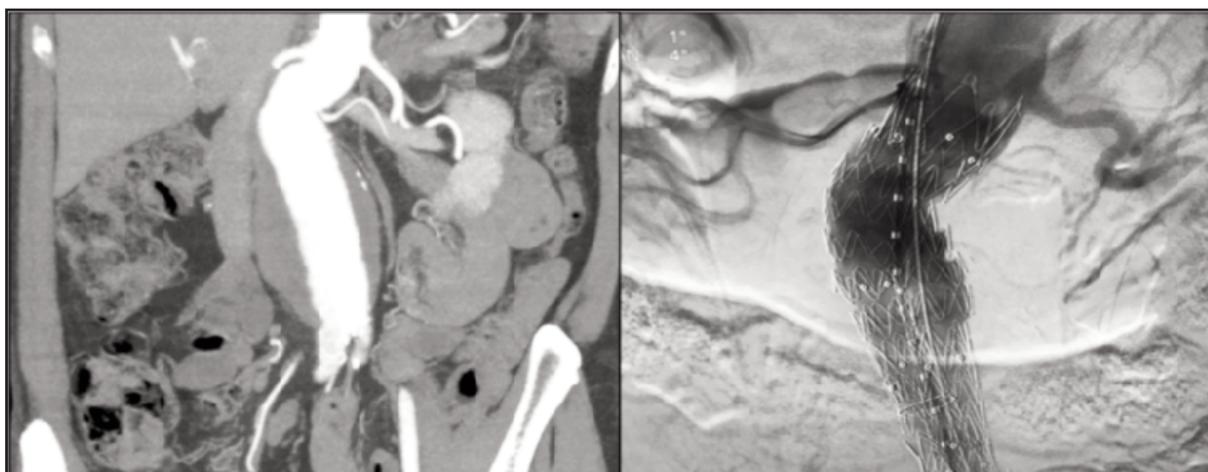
Pre-operative CT Angiogram on the left shows infra-renal abdominal aortic aneurysm with 6cm in the largest diameter. Aortogram on the right shows post endovascular stenting of infra-renal abdominal aortic aneurysm with no endoleak.
